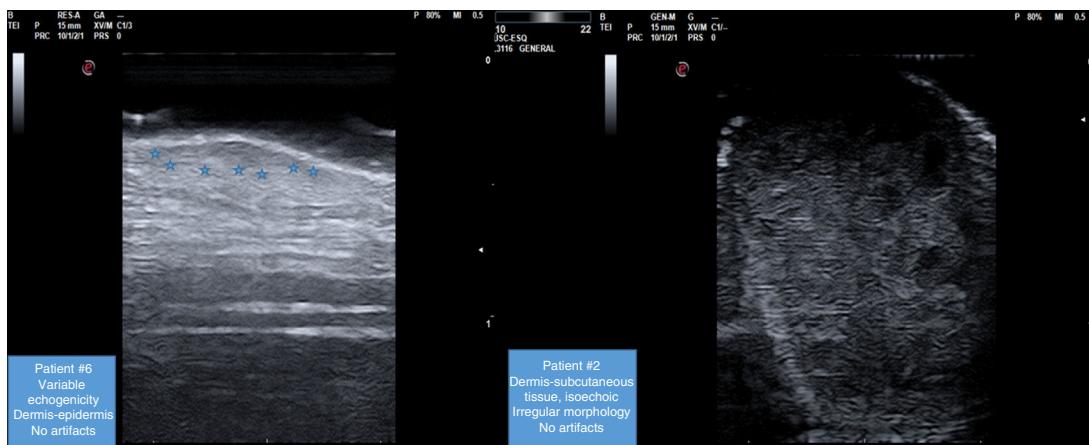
B-mode ultrasound findings of cutaneous metastases in patients #2 and #6.
